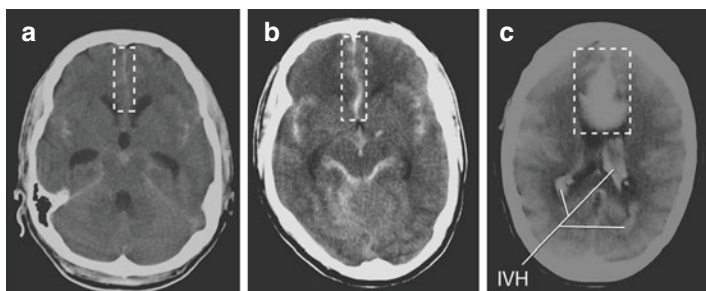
Non-contrast axial CT scans showing different amounts of blood visible in the interhemispheric fissure (dotted boxes in a, b, c). The idea is to look carefully in this location on all the slices with one intention only—to find blood if present! Note carefully that the quality of the CT scan can vary widely even from the same machine due to differences in brightness of the images as produced for you by the radiographer. The intraventricular hemorrhage (IVH) in image (c) is obvious but the overall quality of this image is poor. *If the image quality is unsatisfactory for any reason, then be sure to have a neuroradiologist review the films or have the radiographer repeat them! Can you identify the other locations where blood is seen in this series of scans from three different patients? The Sylvian fissures, third ventricle and ambient cisterns*
